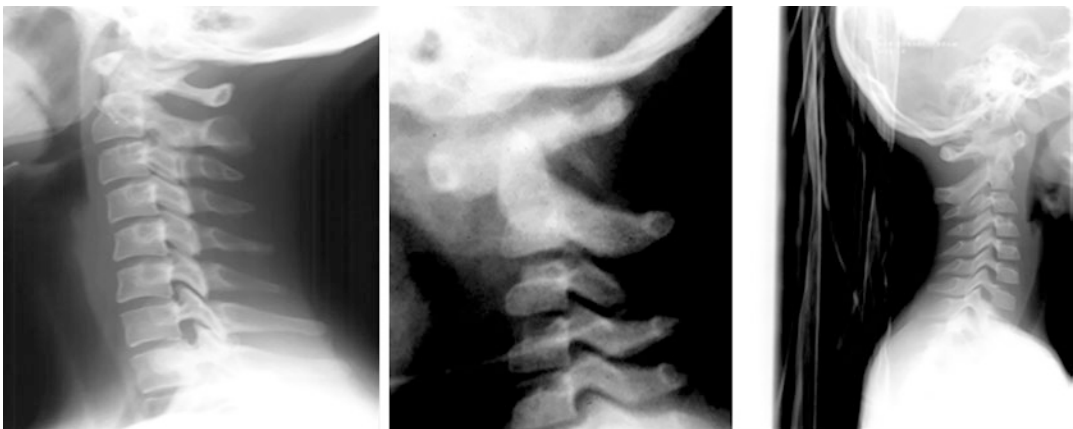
Left: lateral C-spine X-ray showing predental space. Middle: lateral c-spine X-ray showing a widened predental space. Right: lateral c-spine X-ray showing a fractured odontoid process
